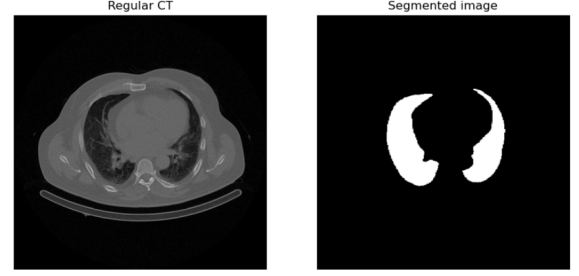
CT slice segmentation
